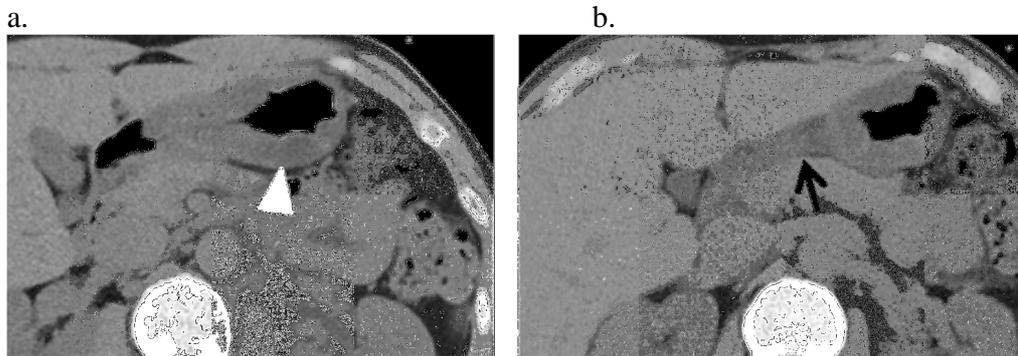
40years old male who complaint acute abdominal pain, anisakis larve was removed by gastro-duodenal endoscopy. a) Convex-shaped and low-density gastric wall thickening (white arrow head) with the finding of gastric wall thickening extended more than two segments and circumferential gastric wall thickening was seen on unenhanced CT. b) Increase of peri-gastric fat density (arrow) was identified more cephalad level of the same CT series.
